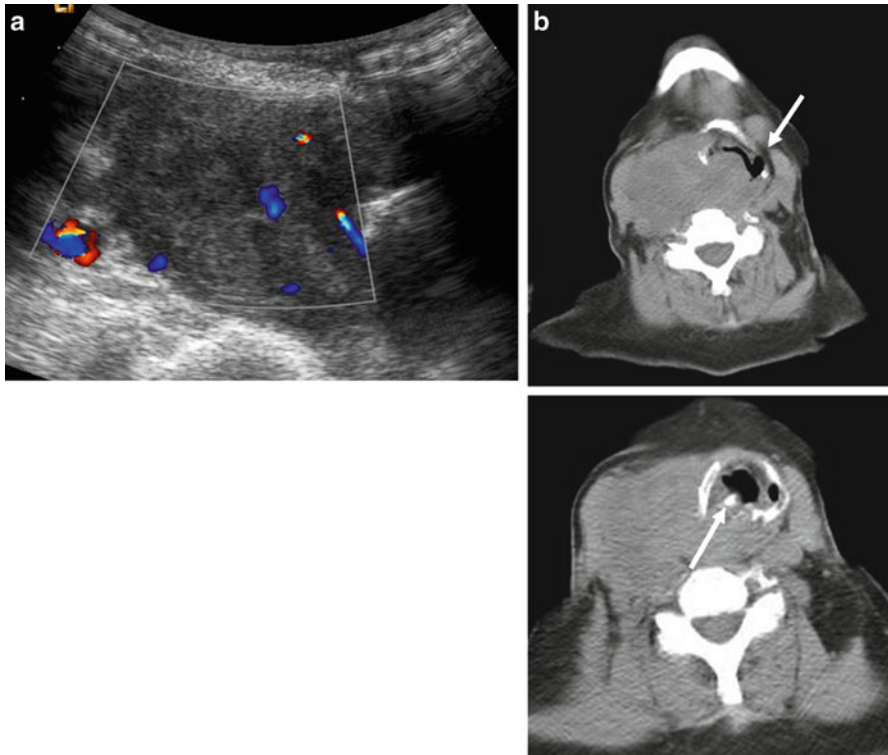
US (a) and CT (b) scans of the neck in a patient with anaplastic thyroid carcinoma. (a) US evaluation confirms the physical finding of a large cervical mass. (b) The severe stenosis of the trachea and the neoplastic infiltration of the upper airway (*arrows*) are clearly only demonstrated by the CT assessment
